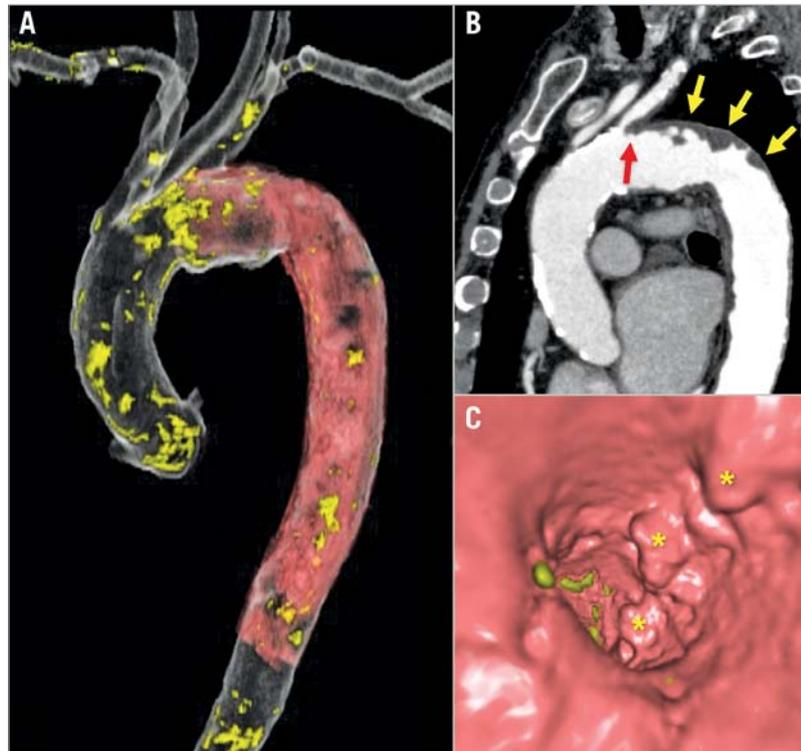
Computed tomography assessment of shaggy aorta. Distribution of calcification is highlighted in yellow and atherothrombotic material is highlighted in red in a three-dimensional volume-rendered image (A). An irregular-shaped atheroma was diffusely observed in the aortic arch (B, yellow arrows) and the ostium of the left subclavian artery was also involved (B, red arrow). Upstream fly-through view indicated that the atheroma was protruding into the aortic lumen (C, asterisks).
